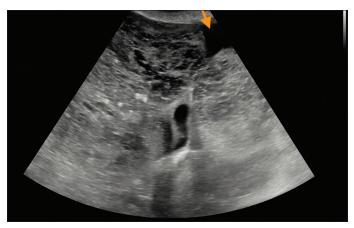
Ultrasound abdomen section obtained with a convex probe shows perihepatic free fluid (orange arrow)
